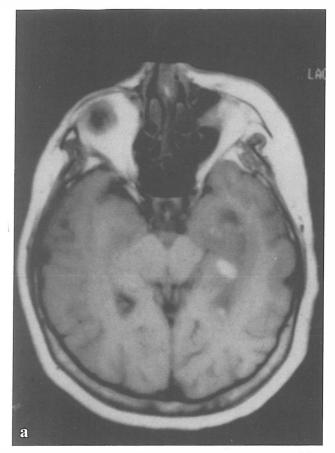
(a-b): Toxoplasmosis solid enhancing lesions; (a) axial and (b) sagittal T1 weighted MR images with Gd. DTPA show multiple small solid enhancing lesions in subcortical and brain stem with surrounding edema.
